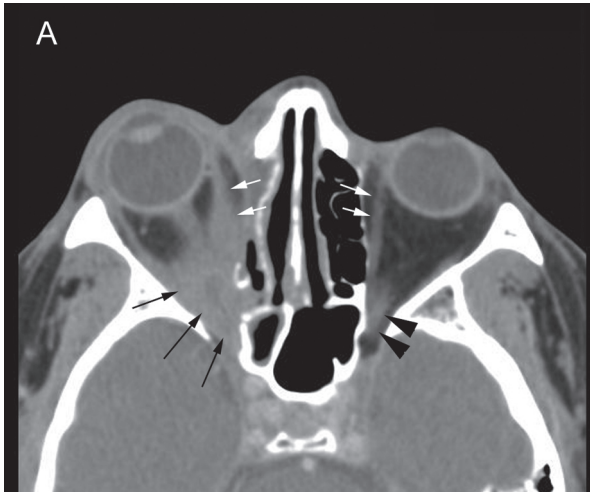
High-resolution axial computed tomographic (CT) images obtained without contrast through the maxillofacial area after 33 days of amphotericin B therapy.
